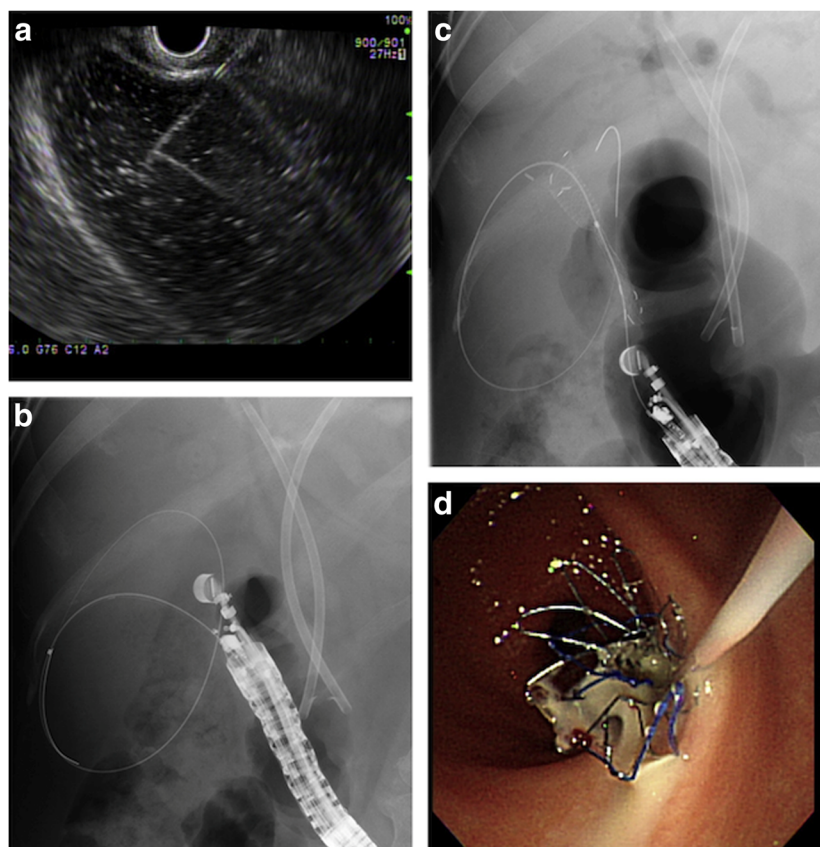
a EUS image showing needle tip in the gall bladder (GB). b Guidewire coiled in the GB under fluoroscopic guidance. c SEMS Proximal flange deployed in the GB. d distal flange of the cSEMS opened in the gastric lumen. *Gastrointestinal Intervention, Can endoscopic ultrasound help to drain the gallbladder?*, 2, 2013, p. 30–35, Choi JH, Park DH, Lee SS, Seo DW, Lee SK, Kim MH, (Copyright © 2013, Society of Gastrointestinal Intervention) “With permission of Do Hyun Park”.
